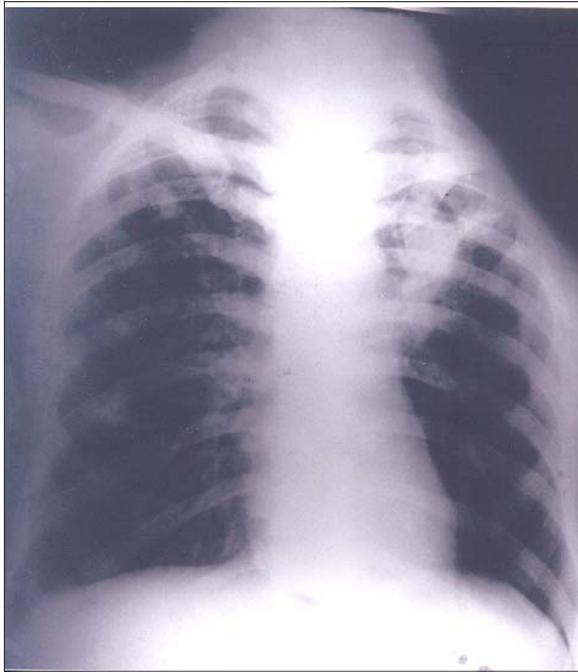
X-ray chest showing a cavitary lesion with an intracavitary mass in left upper-zone.
